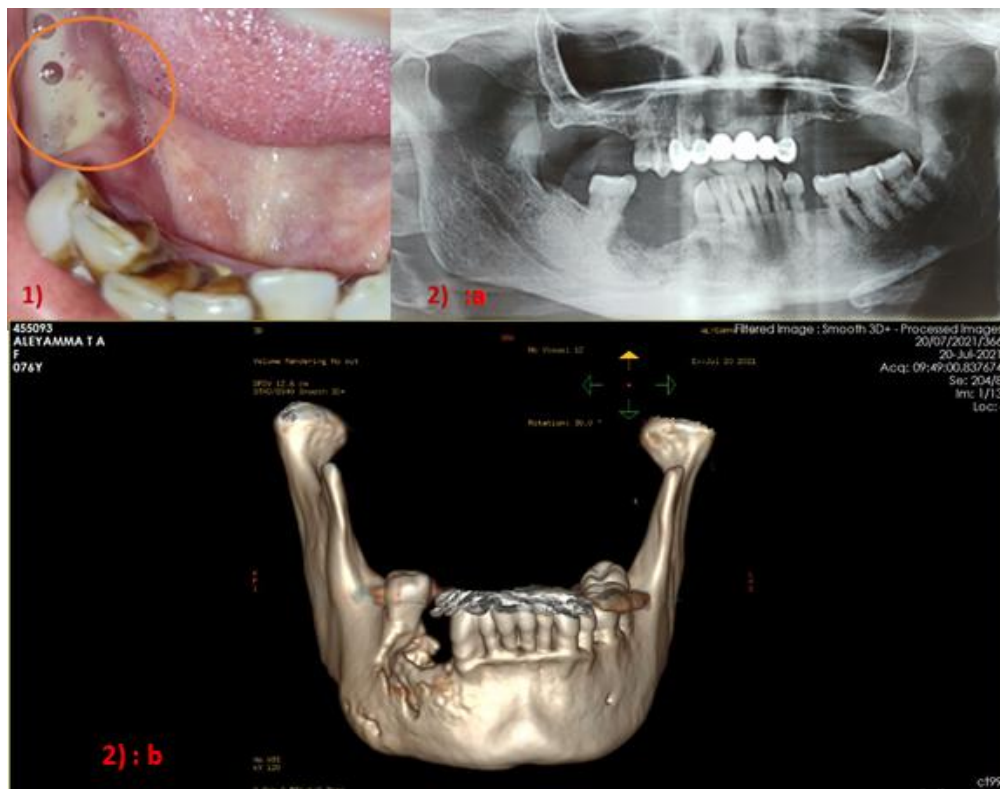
Pus discharge from extraction socket, Fig. 2a. OPG one year extraction, Fig. 2b. 3D CT mandible
